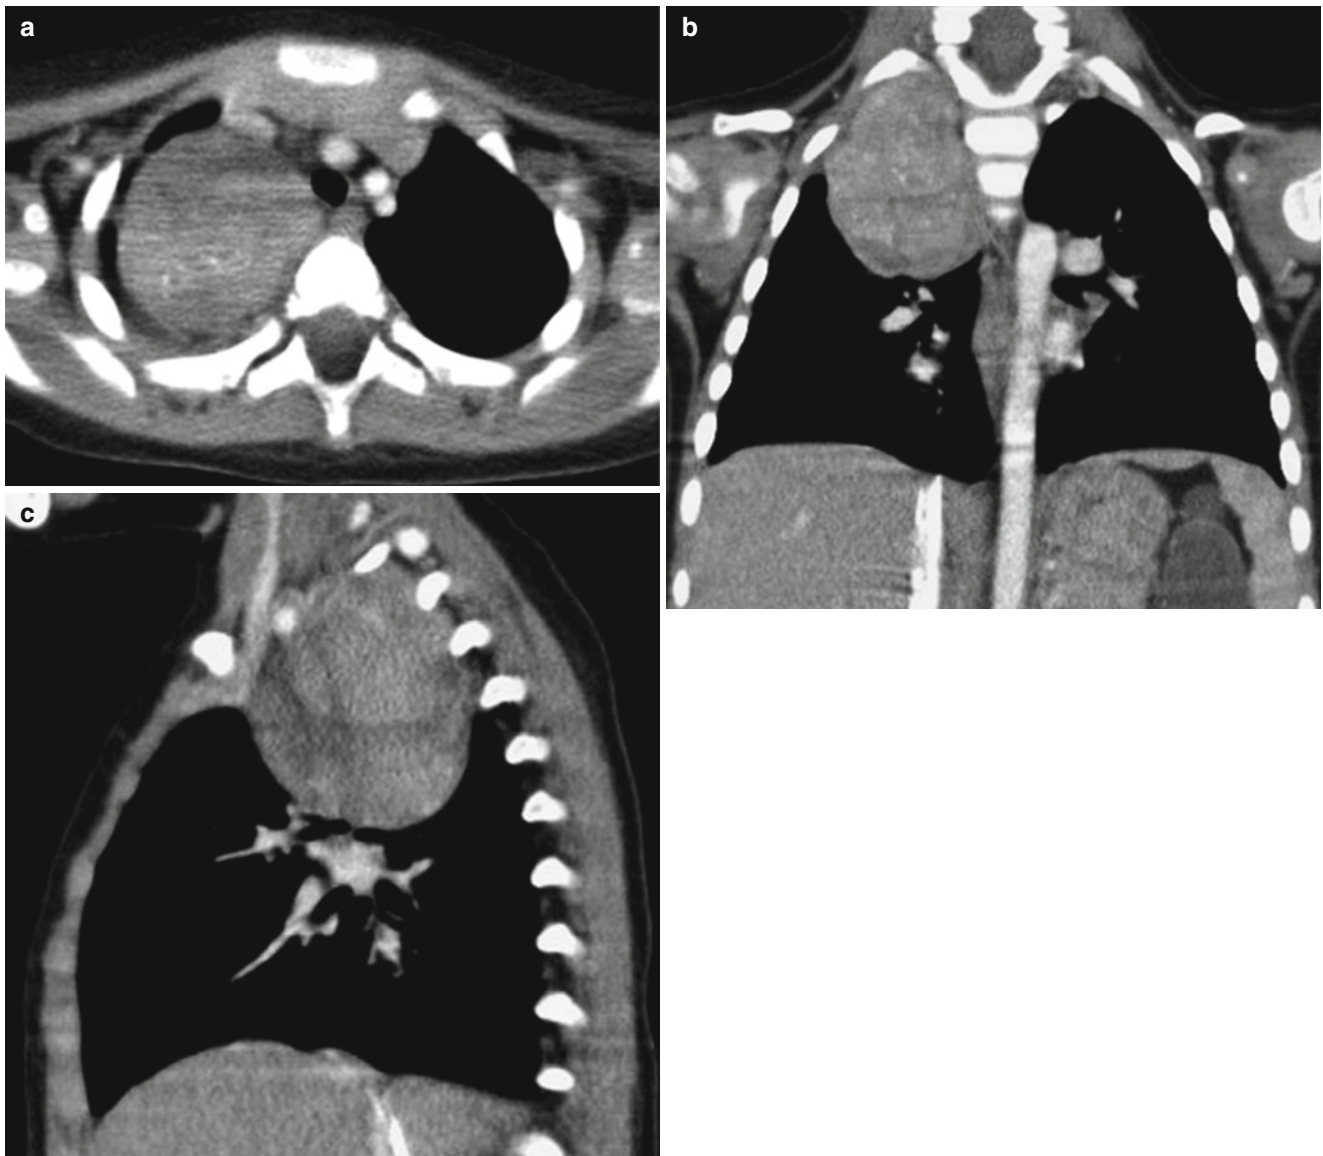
Ganglioneuroblastoma in a 4-year-old girl with vomiting and diarrhea. (a) Axial contrast-enhanced CT shows a relatively well-defined enhancing paraspinal soft tissue mass with coarse
